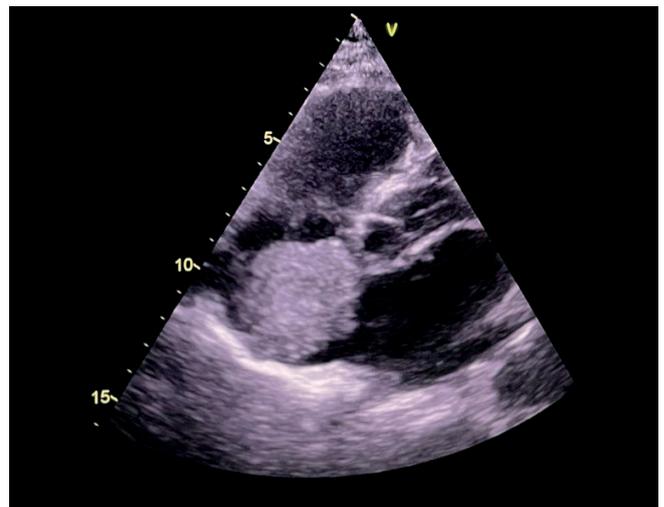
The right atrium tumour of comparable size as noted in the computed tomography (approx. 5 x 5 cm) – transthoracic echocardiography performed upon admission to the Department of Cardiology
